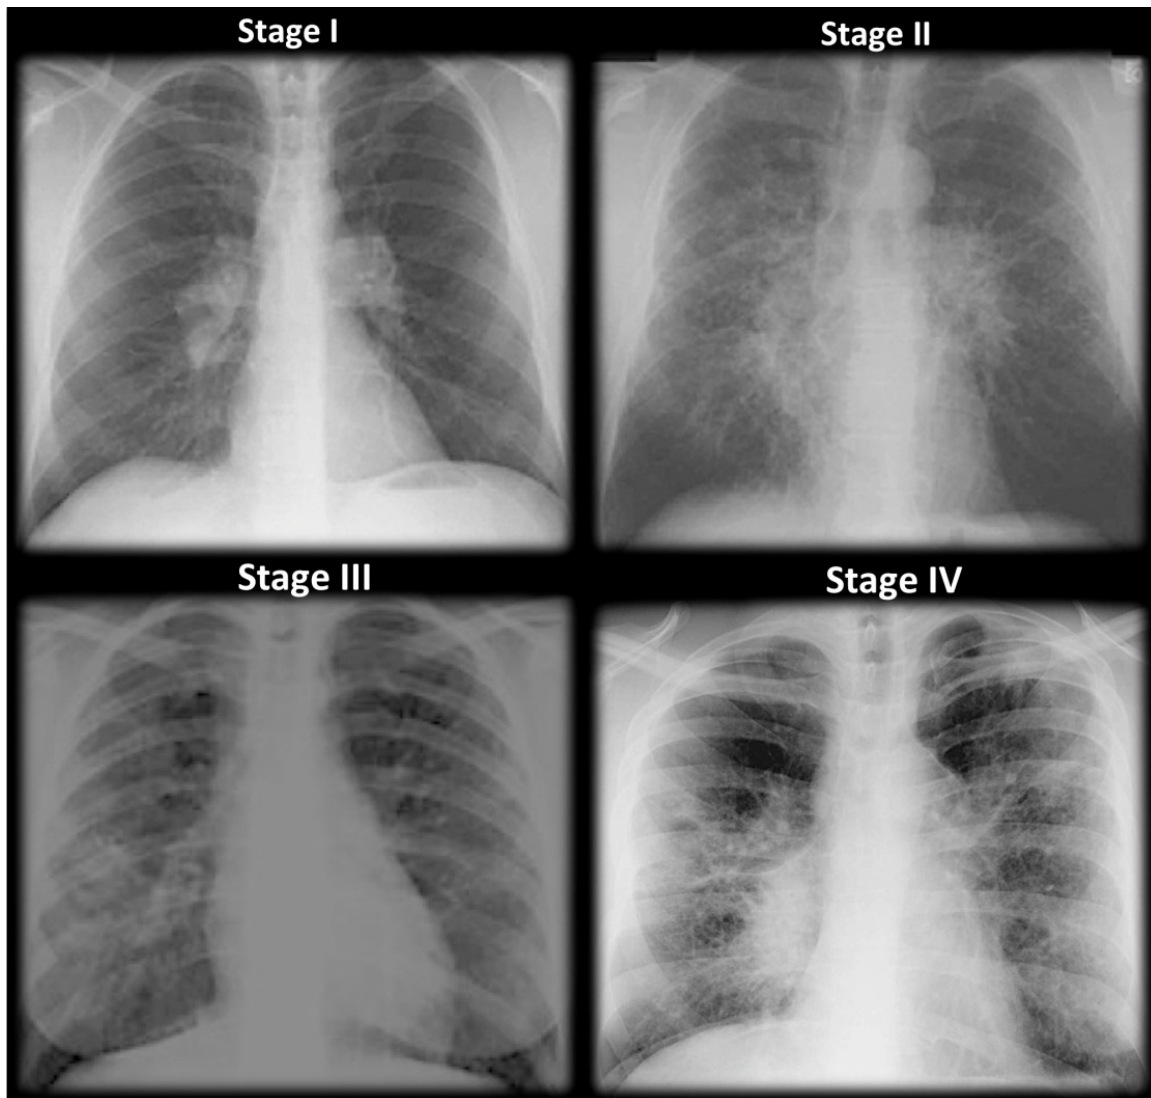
Staging of sarcoidosis on basis of chest radiographs
